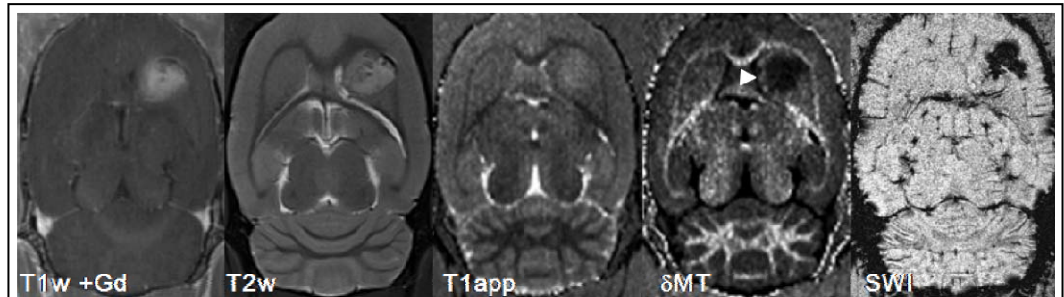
Multiparameter-MRI of native C6-glioma 21 days after tumor cell injection
